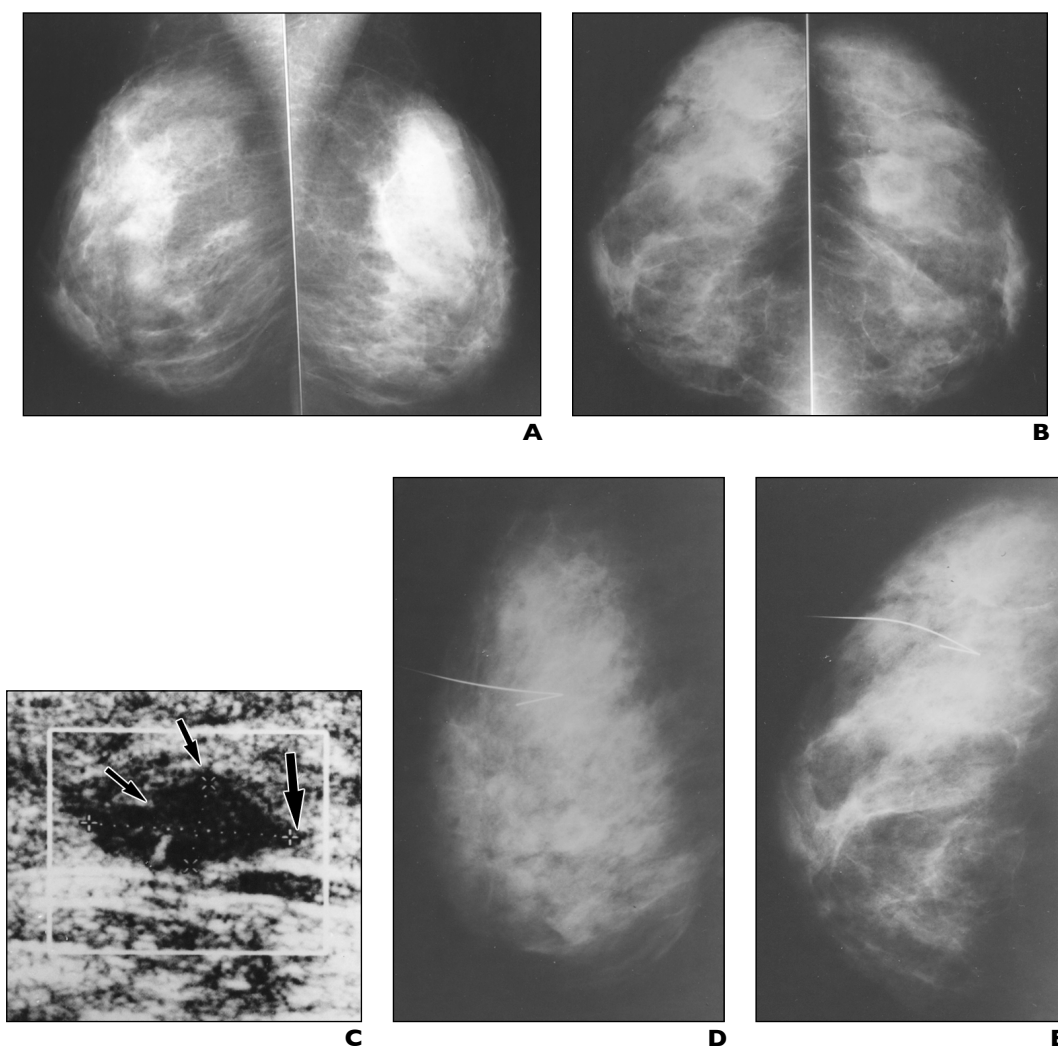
67-year-old woman with dense Breast Imaging Reporting and Data System (BI-RADS) [14] category 3 breast tissue. A and B, Mediolateral oblique (A) and craniocaudal (B) screening mammograms reveal no abnormalities. C, Screening sonogram shows solid hypoechoic mass that measures 9 mm wide by 5 mm high. Angular margins (*arrows*) between mass and surrounding tissues are suspicious for malignancy. Sonographically guided biopsy (not shown) revealed invasive ductal carcinoma. D and E, Right mediolateral (D) and right craniocaudal (E) mammograms obtained after sonographically guided wire localization show uniformly dense breast tissue with no evidence of mass in hookwire area.
